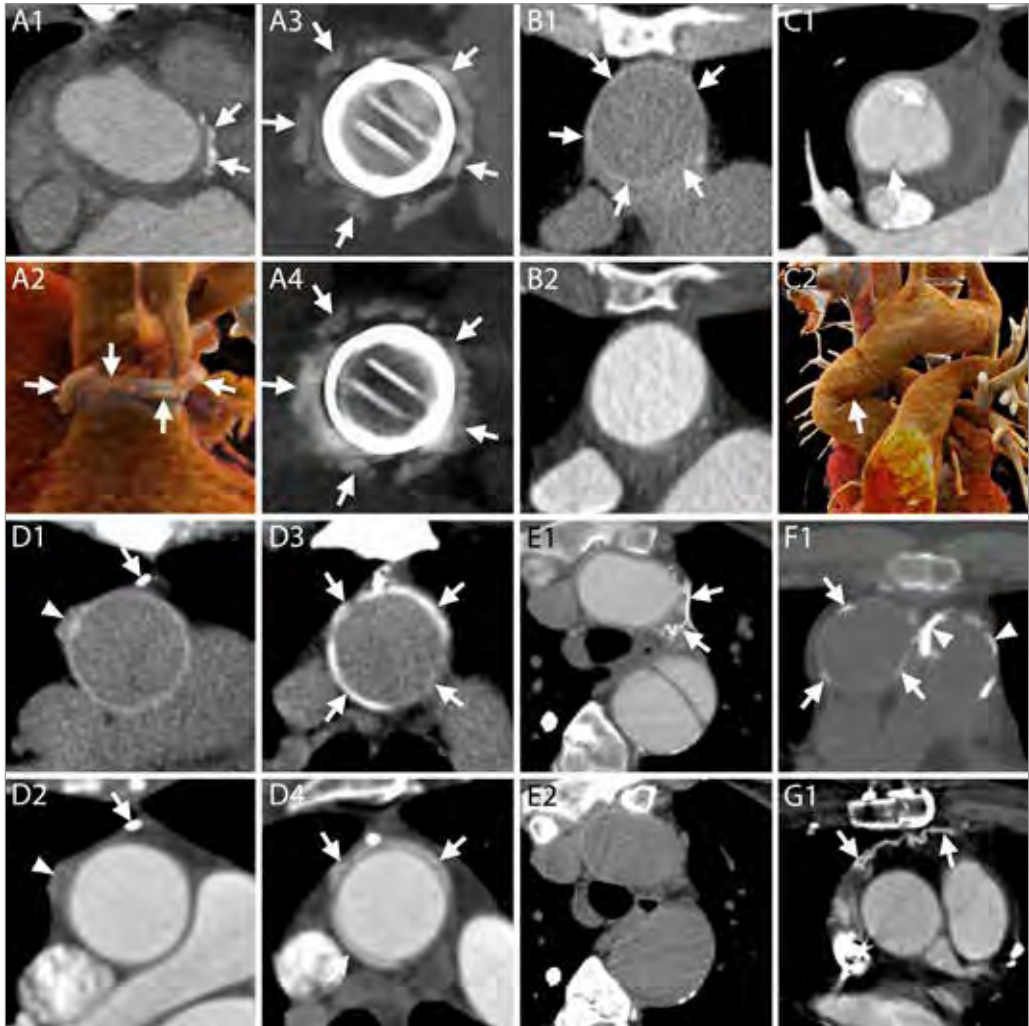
Surgical material and potential pitfalls. A1-A4 –CT appearance of pledgets. After a Bentall procedure or surgical aortic valve replacement, hyperdense material can be seen around the aortic root on axial images (A1, arrows). These hyperdense images represent pledgets that are employed by surgeons to reinforce the sutures on the suture ring of the valve and should not be mistaken for extravasated contrast. The material can be seen surrounding the junction of the LVOT and the aortic root (A2, arrows), at a short distance from the valvular ring (A3, arrows), although generally not all on the same plane (A2). An un-enhanced acquisition can be useful to assess the presence of the images also before contrast administration and confirm their nature (A4 arrows). A1 – Axial image. A2 - 3D reconstruction. A3-A4 - MPR with maximum intensity
